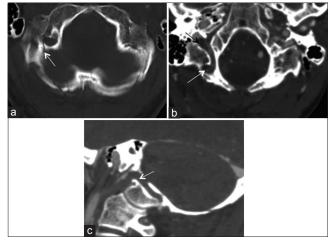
Axial CT scan demonstrates linear occipital bone fracture with extension to the right posterior condylar canal (a white arrow). Axial and sagittal oblique CT Venogram (b and c) demonstrate right condylar vein thrombosis (white arrow) with extension to right internal jugular vein (black arrow)
